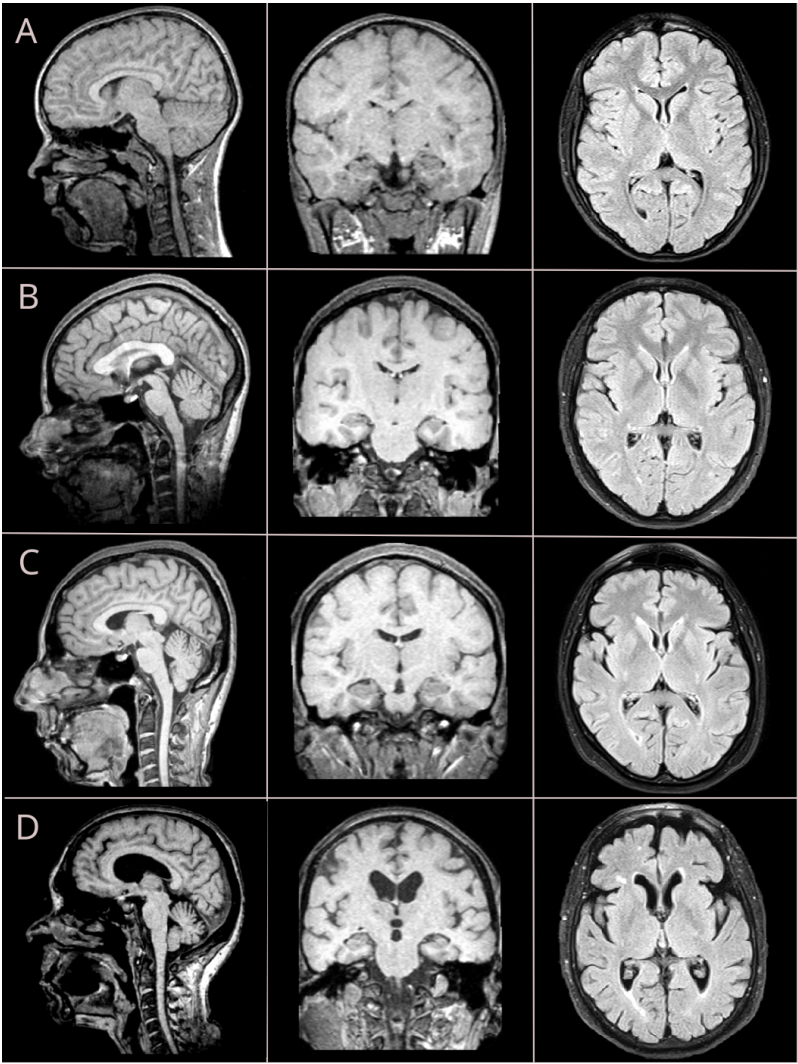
Brain MRI changes throughout 4 stages marked from A to D: adolescence, early adulthood, middle, and old age. T1w sequence with isometric (3D) vowel is used to reconstruct sagittal and coronal views; FLAIR sequence is used to retrieve axial images
